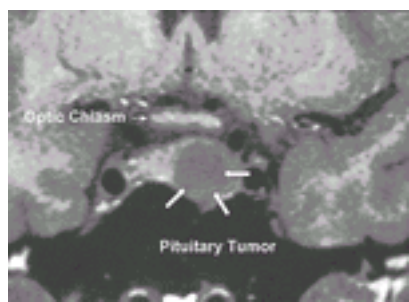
A pituitary tumor. Magnetic resonance imaging of a prolactin-secreting pituitary tumor (*three large arrows*). Note the lateral location and elevation of the diaphragm sellae. However, the tumor does not compress the optic chiasm (*single arrow*) and thus no visual disturbances would be anticipated.
